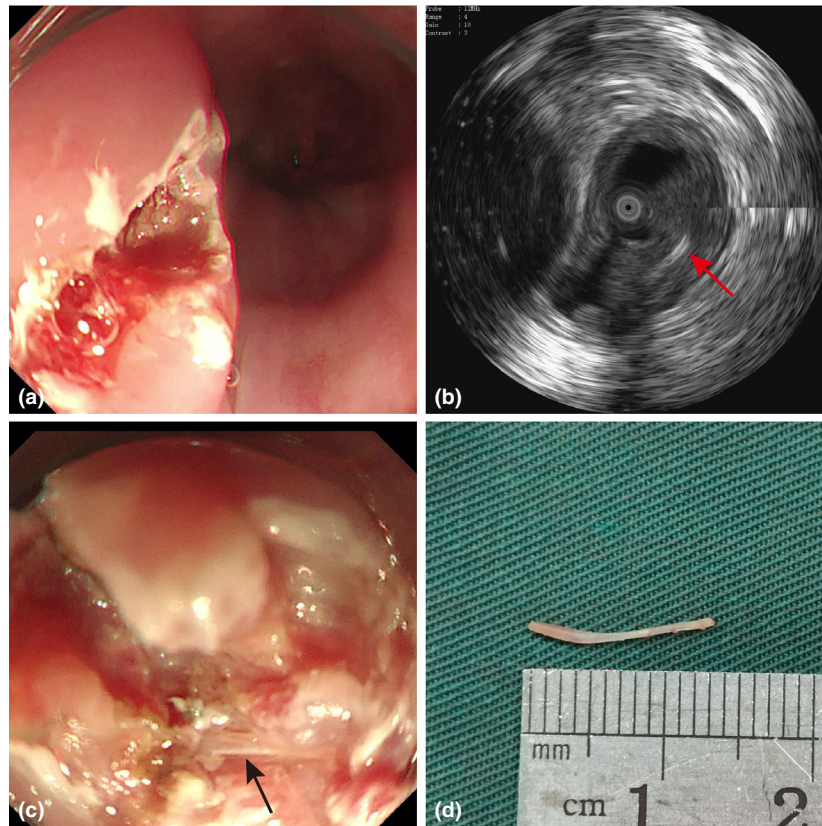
(a) No foreign body was observed after incision along the longitudinal axis of the esophagus. (b) Detection of the buried fishbone using real-time miniprobe endoscopic ultrasound. (c) Fishbone embedded in the muscularis propria was revealed at the marked position. (d) Length of fishbone measured after removal, which was approximately 1.4 cm in length.
